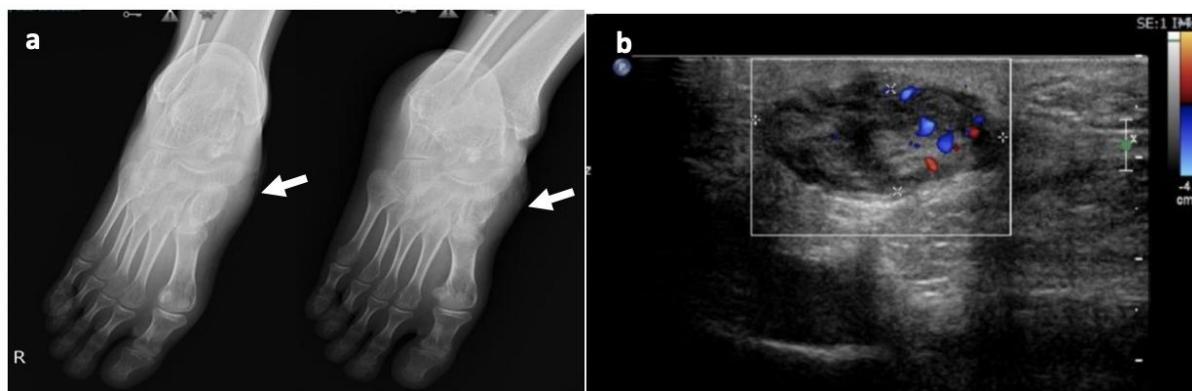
a) X-ray examination of the right ankle with AP/Oblique projection revealed a soft tissue swelling with minimal erosion of the surrounding tarsal bones and no apparent bone destruction or periosteal reaction (arrow), concluded as a soft tissue tumor, b) Ultrasonography of the plantar pedis confirmed a hypoechoic and heterogeneous mass at the thickness of the plantar fascia with significant vascularization in Doppler.
